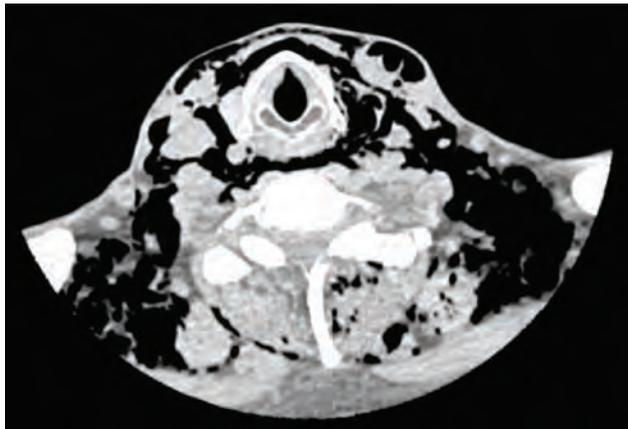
CT scan of the neck shows large amount of air in the subcutaneous tissue of the neck.
